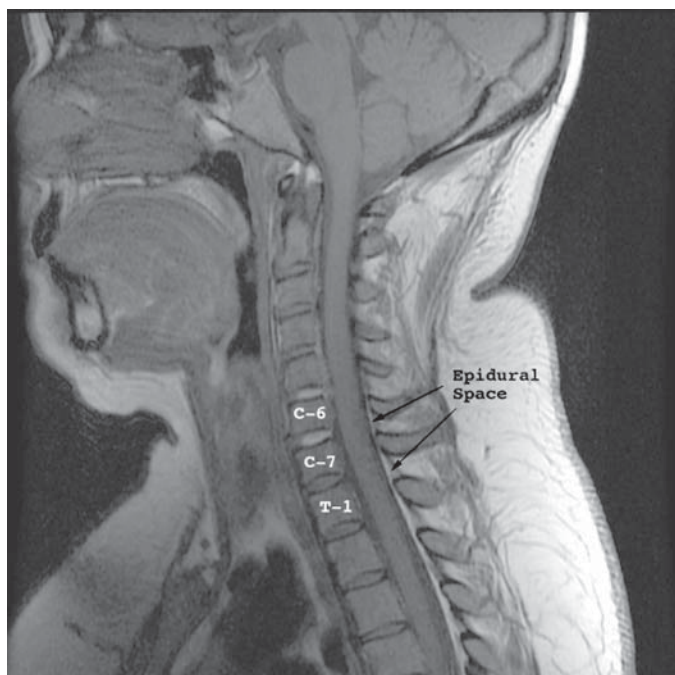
This sagittal MRI of the cervical spine shows the more prominent epidural space at the C6–7 and C7–T1 interspaces.
